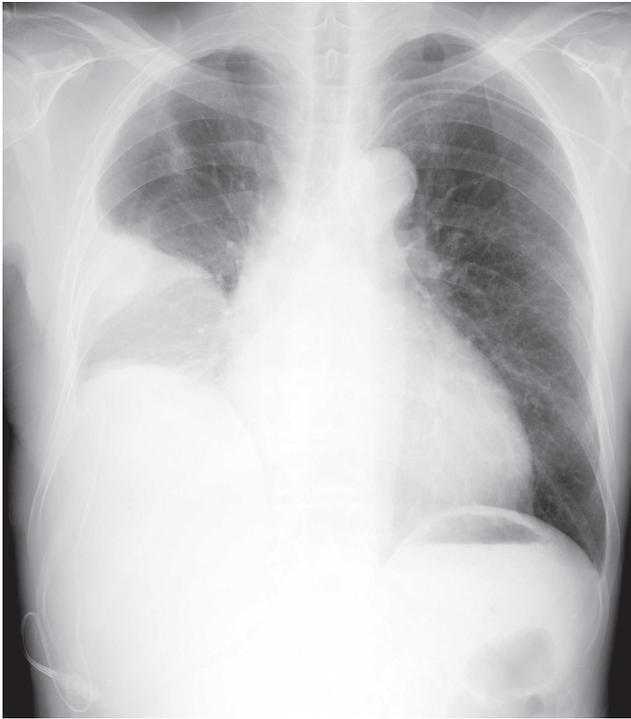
Massive pleural effusion in the right hemithorax and pericardial effusion in a chest radiograph.
